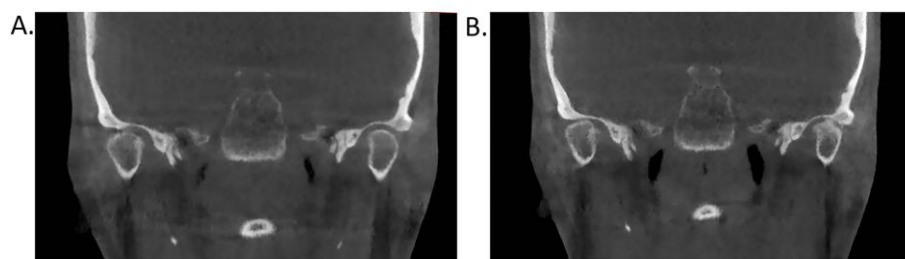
CBCT imaging. A. Preoperative normal condyle. B. Early osteoarthritis signs of left condyle at 2 years follow-up.
